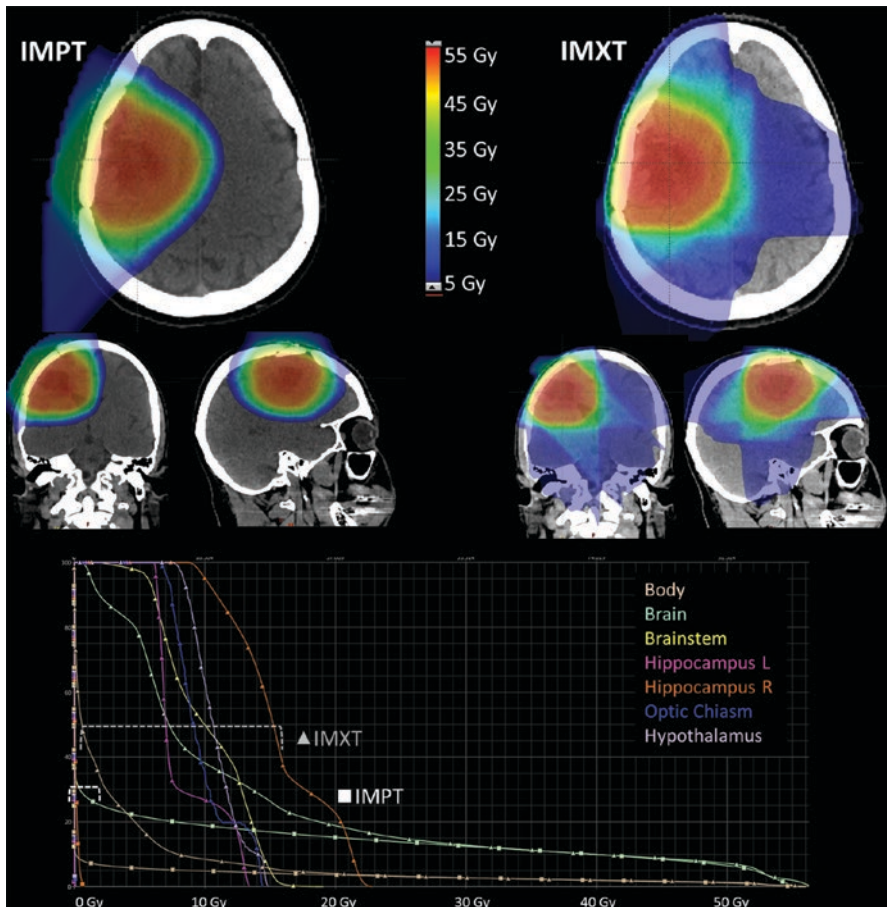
Isodoses and dose volume histogram comparison of proton IMPT and X-ray IMRT radiation plans for a right frontal low grade astrocytoma treated after resection. Overall dose to all adjacent normal structures is lower with the proton plan
